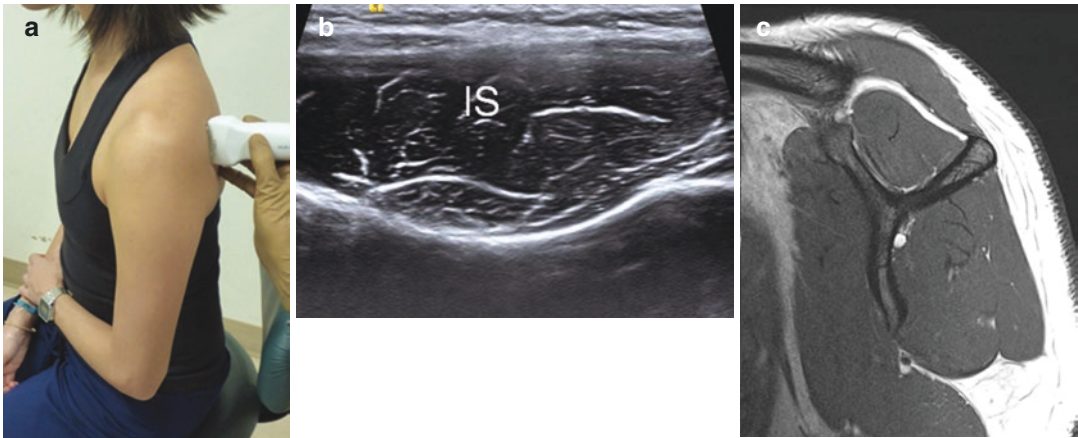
Muscle imaging—infraspinatus patient positioning (a); short-axis sonographic image (b); MRI correlate (c); infraspinatus (IS)
